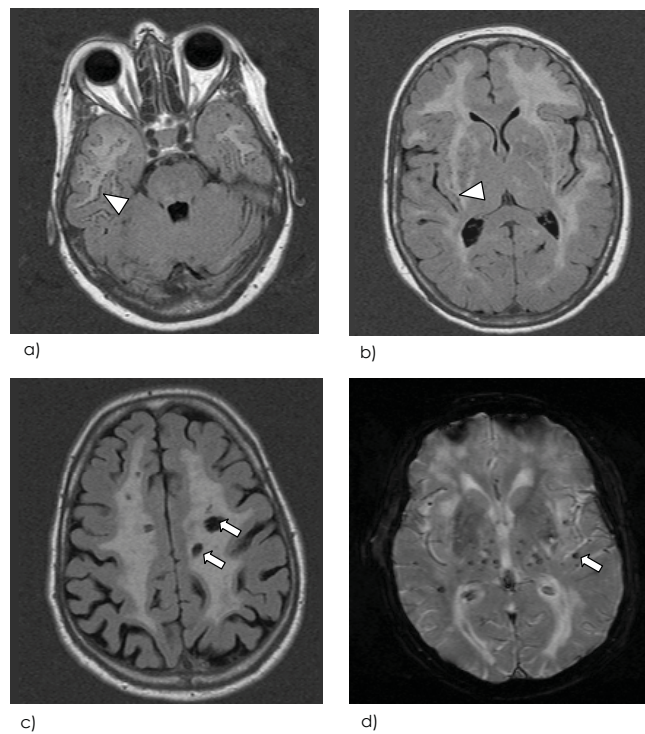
Axial FLAIR MR images(a-c). T2*-weighted gradient-echo MR image(d). Images obtained in *NOTCH3* mutation carriers who were 51-60 years old show complete penetrance of CADASIL: confluent areas of hyperintensity (a-c), lacunar infarcts (arrows in c), SLLs (arrowheads), and microbleeds (arrow in d).
